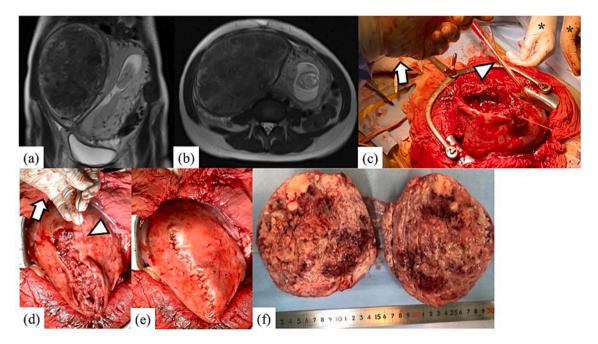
(a) Coronal and (b) horizontal magnetic resonance images at 14 weeks of gestation showed a giant myoma measuring 16×11 cm superior to the uterine cavity. (c, d) During myomectomy, reconstruction of the uterine wall is performed by an assistant surgeon using monofilament absorbable 0 barbed sutures (STRATAFIX® Spiral PDS® PLUS; ETHICON, Tokyo, Japan) without applying extra force that would otherwise apply pressure to the uterus (asterisk). The left hand of the operator (white arrow) is able to pull the barbed suture alone (white triangle). (e) The uterine serosa is closed with a continuous baseball suture using monofilament absorbable 3.0 sutures (PDS® II; ETHICON, Tokyo, Japan). (f) The removed myoma weighs 1173 g.
